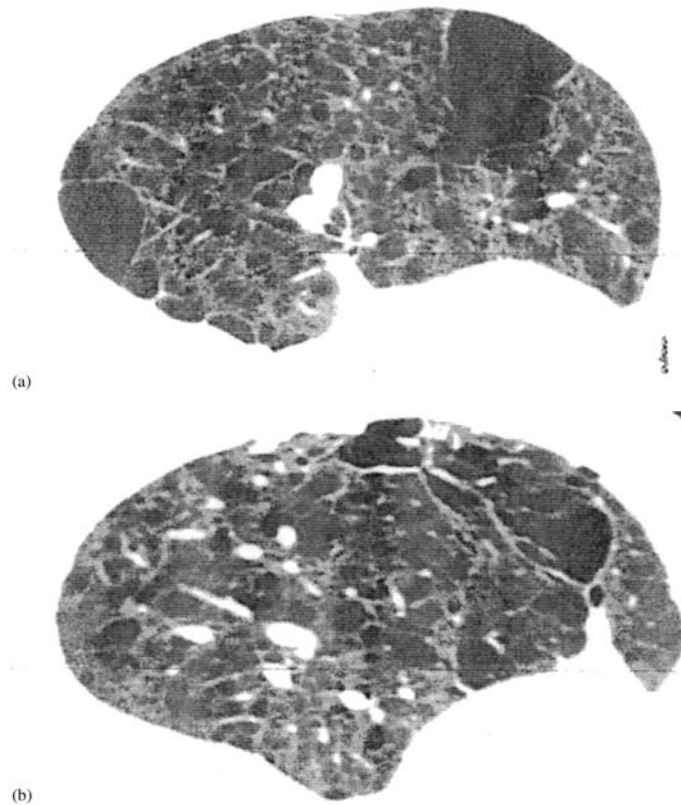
(a) Lymphangiomyomatosis. CT in a 44-year old woman with LAM demonstrates multiple, thin-walled cystic radiolucencies. Note the two large lesions, representing confluent cysts. (Reproduced with permission. From Ref. 85.) (b) Lymphangiomyomatosis. HRCT from the same patient showing innumerable well-defined cysts. The cysts are distributed diffusely, without a propensity for a particular region or zone of the lung.
